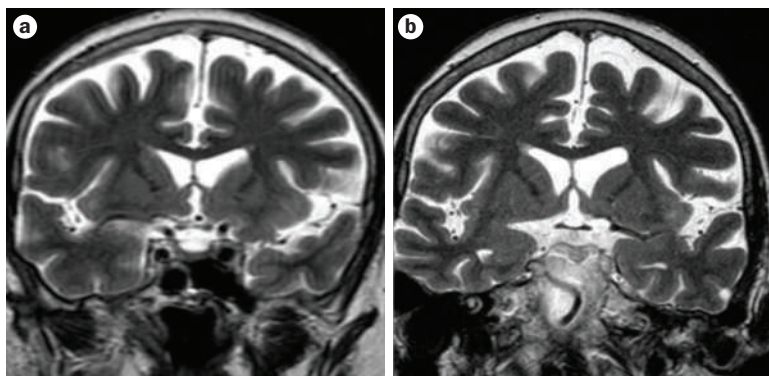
Brain MRI scans from a patient with behavioral variant frontotemporal dementia. Coronal MRI scans through the frontal lobes, indicating progressive frontal lobe degeneration. Frontal atrophy was assessed by means of a validated visual rating scale,⁴ which uses T1-weighted coronal images through the frontal and anterior temporal lobes and rates regional atrophy on a four-point scale (0=no atrophy; 1=mild atrophy; 2=moderate atrophy; 3=marked atrophy). a | MRI scan of the case patient taken on initial presentation; frontal atrophy rated at grade 1. b | MRI scan taken 2 years after initial presentation showing more-severe frontal atrophy (grade 2).
